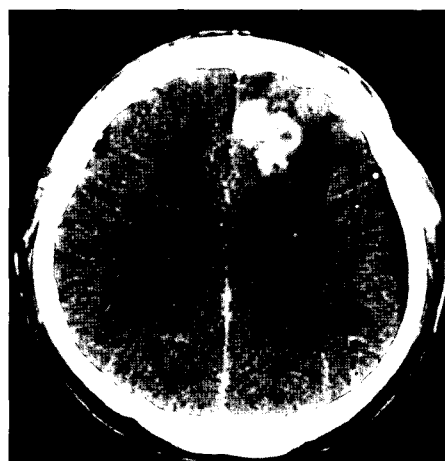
CT at three months after the radiation therapy in Case 1. Nodular and irregularly margined mass is seen in the left frontoparietal lobe, showing dense homogenous enhancement. The surrounding low density edema is also seen. The mass is markedly reduced after the radiation therapy.
